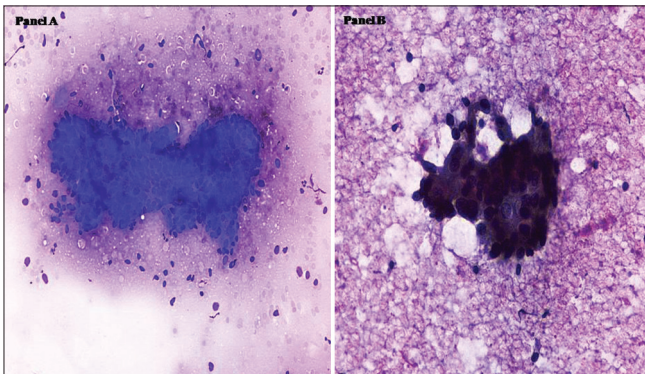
Panel A showing computed tomography-guided fine needle aspiration cytology from splenic lesion showing cluster of atypical epithelial cells with acinar formation (Giemsa, ×100). Panel B showing computed tomography-guided fine needle aspiration cytology from splenic lesion showing cluster of atypical epithelial cells with acinar formation (Pap, ×200)
